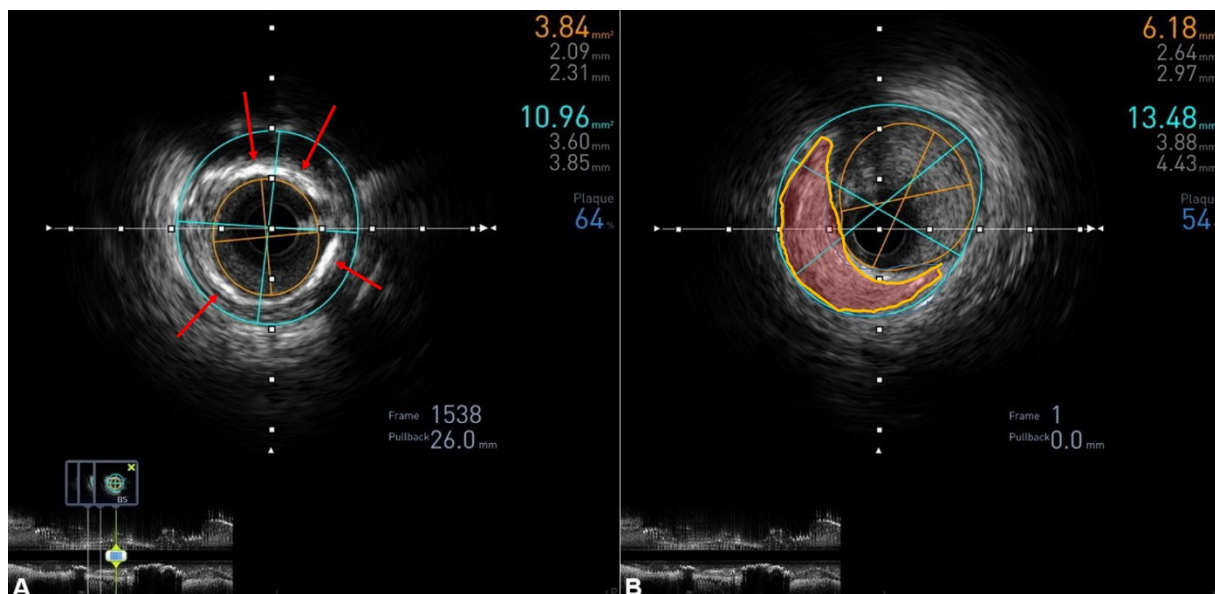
Intravascular ultrasound of left anterior descending (LAD) artery shows A) circular stenosis of 64% of mid LAD (minimal luminal area – MLA = 3.84 mm^2) with calcification (red arrows) and B) eccentric plaque of ostial part of circumflex artery with stenosis of 54% (MLA = 6.18 mm^2) (red field).
